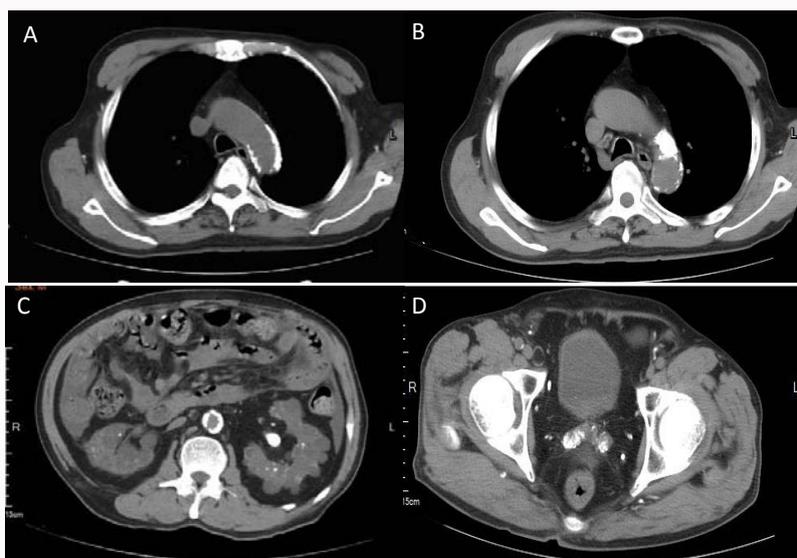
Chest and abdomen CT.
